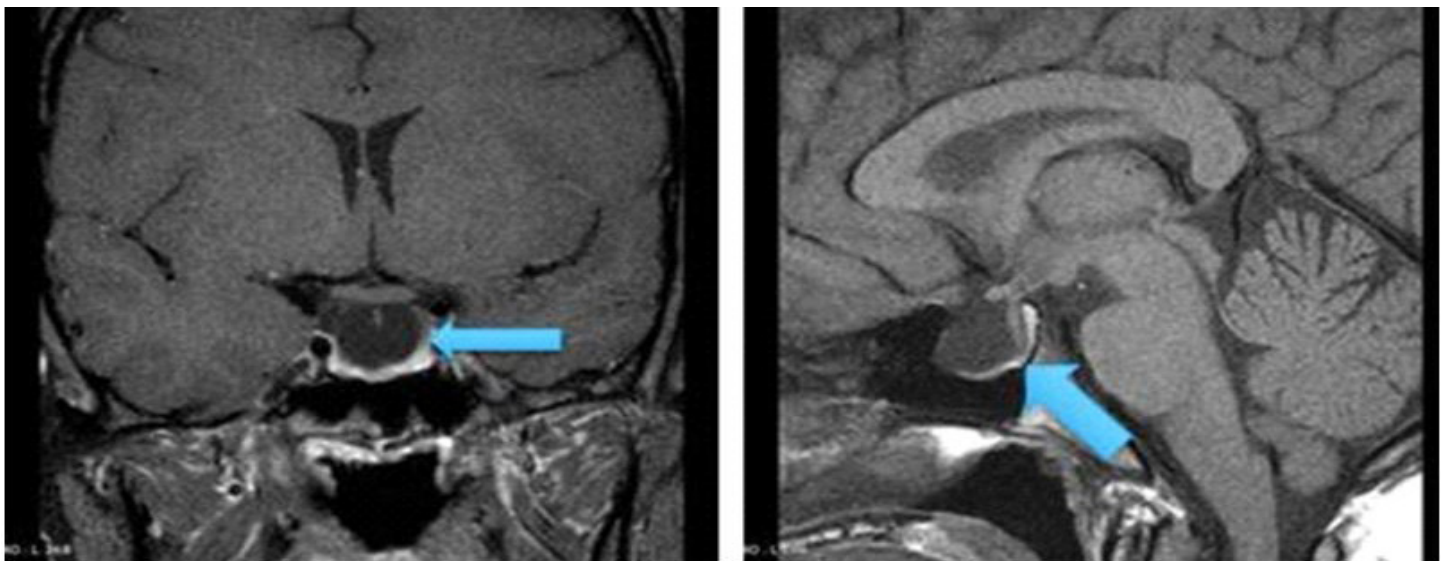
Magnetic resonance imaging of the patient's brain, showing an empty sella turcica (blue arrows) in coronal (left) and sagittal views (right).
